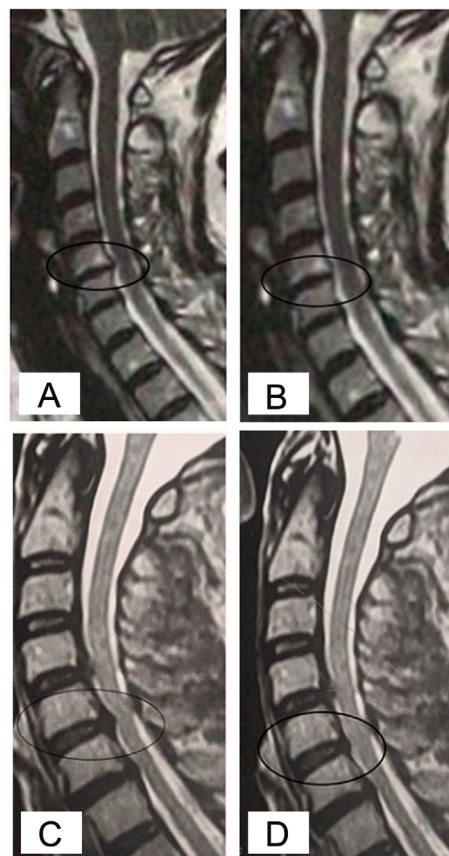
(A) Sagittal cervical MRI pre intervention and (B) 3 months post intradiscal ozone injection showing decrease in disc size (C5-6 disc). (C) Sagittal cervical MRI pre intervention and (D) 3 months post intradiscal ozone injection showing decrease in disc size (C5-6 disc).
